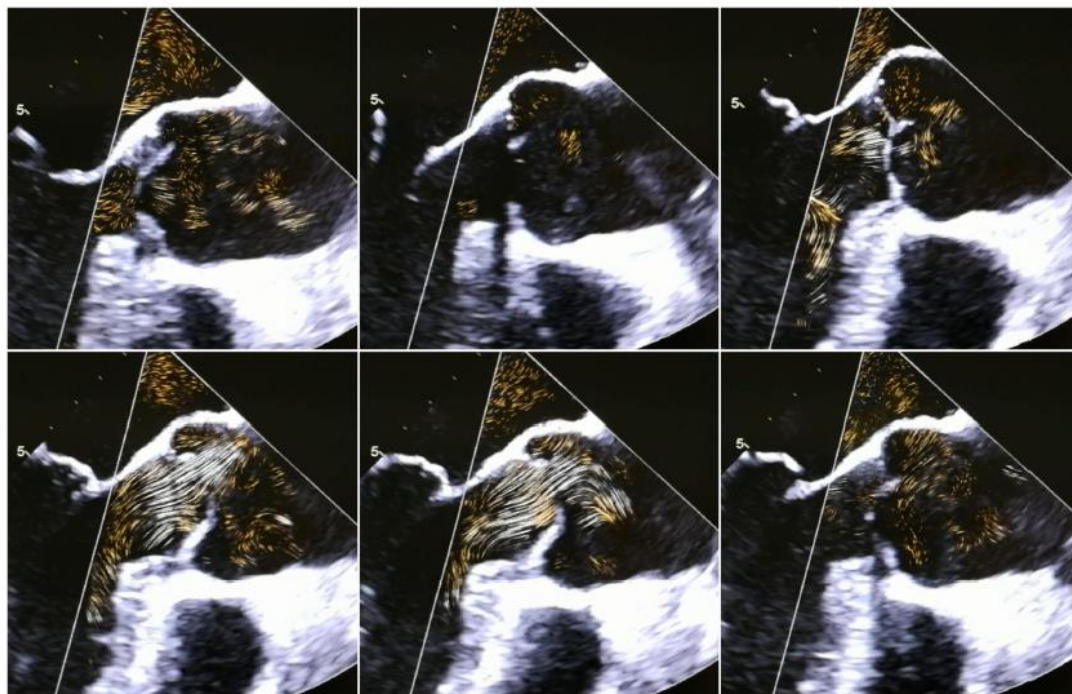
2D transesophageal long axis views within one cardiac cycle showing the blood flow by blood flow speckle tracking. This new technique permits the visualization of the flow vortex.
